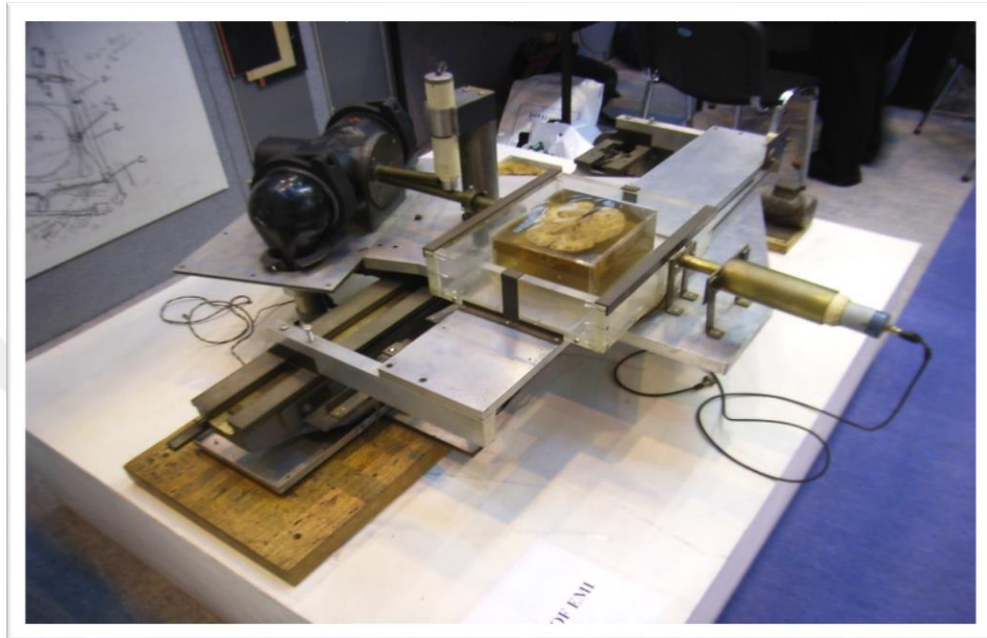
Hounsfield's prototype CT scanner [12].
